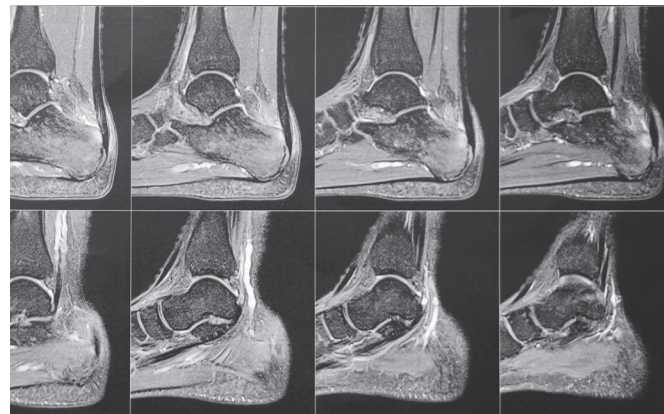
Sagittal MRI view of the heel.
